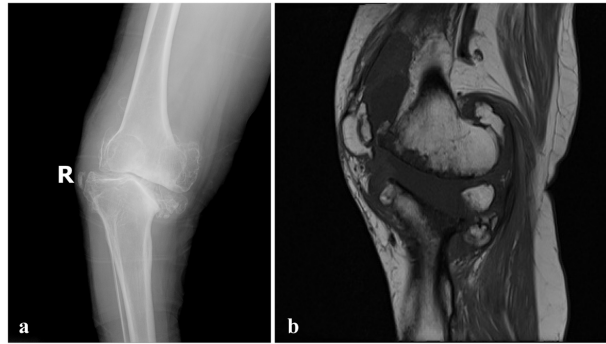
Anteroposterior radiographs and magnetic resonance imaging scans of the patient. Radiograph shows degenerative change and osteophytes in the left knee joint (a) and narrowing the joint space and severe joint destruction (b).
